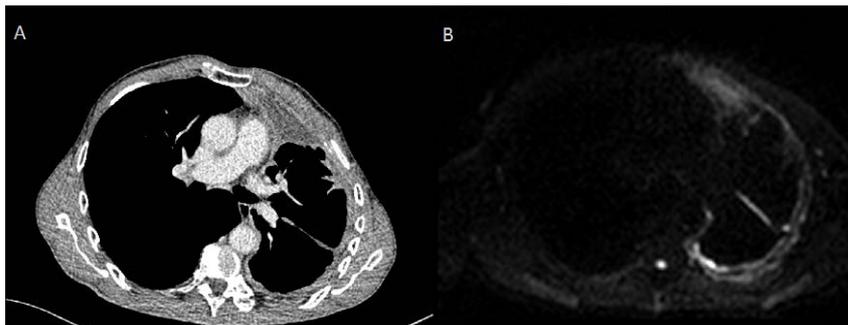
(A.) CT and (B.) DWI images of b at 800 mm²/s of a 69-year-old male with mesothelioma in the left lung. Both CT and DWI images show the shrinkage
